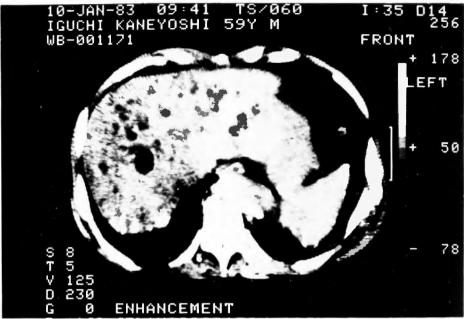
Abdominal CT showing multiple cysts in liver
